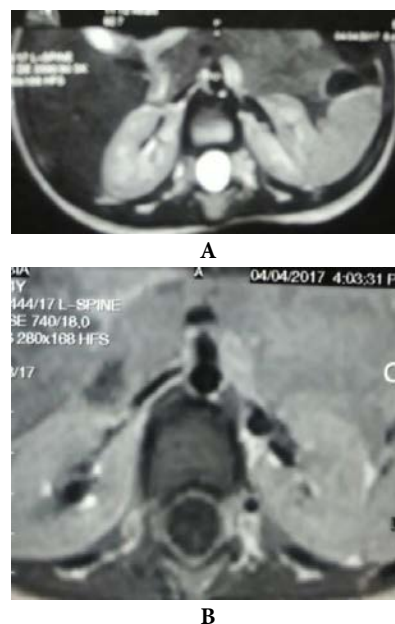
MRI T2WI of dorsolumbosacral spine, axial section showing wellcircumscribed, hyperintense, cystic lesion
